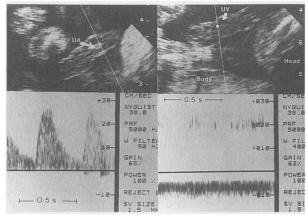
A pulsed Doppler interrogation of the umbilical cord also provides important hemodynamic information. Left, The Doppler sample volume lies within the umbilical artery (UA, arrow). In the lower panel, a characteristic umbilical arterial signal is displayed above the baseline showing flow toward the transducer. Right, The Doppler sample volume is within the umbilical vein (UV, arrow); the fetal body and head are also seen. In the lower panel, a Doppler signal of uniformly low velocity throughout systole and diastole is demonstrated below the baseline. The blank space between the baseline and Doppler signal is the result of a high wall-filter setting (from Schmidt and Silverman<sup>48</sup>).
